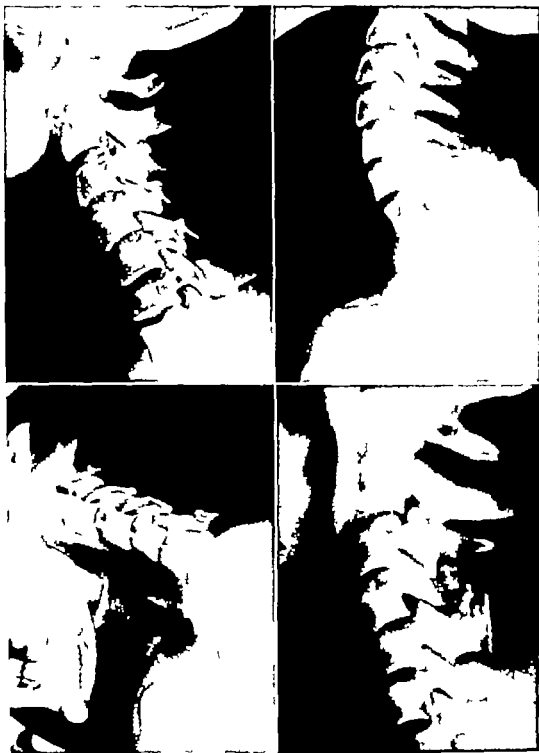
(*Top left*) Lateral view of cervical spine of male, 21 years old 8 weeks following trauma to the cervical spine (by whip-lash mechanism) Observe that the normal forward cervical curve is straightened particularly in the segment formed by the fourth, fifth and sixth cervical vertebrae. (*Top right*) Lateral view with spine hyperextended (same patient) (*Bottom left*) Lateral view with spine hyperflexed (same patient) Note the forward displacement of the fourth cervical on the fifth cervical vertebra. The outstanding symptom in this case was pain radiating into both shoulder and right arm accentuated by forward bending of the neck. Observe the increased interval between the spinous processes of the fourth and fifth vertebrae. (*Bottom right*) Same patient 7 months after injury Note the alteration of the cervical curve and increased forward displacement of the fourth on the fifth cervical vertebra ("creeping migration") This roentgenogram was taken 8 weeks after a fusion of the fourth and fifth cervical vertebrae had been done. Coalescence of the bone chips is discernible. This patient was seen for the first time 8 weeks after the injury (his head was snapped forward when the automobile he was driving was forcibly struck in the rear) No treatment had been rendered during this period. A hyperextension collar was then applied which relieved the symptoms he wore the collar for 12 weeks symptoms returned when the collar was removed A spinal fusion (as shown above) was then performed
